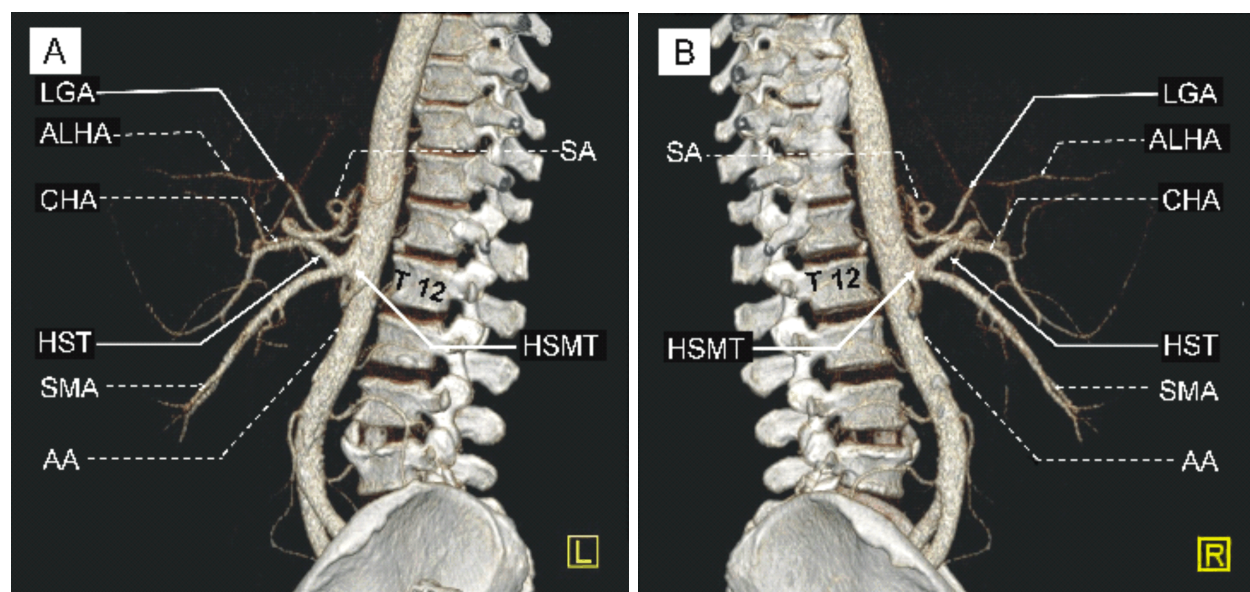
MDCT angiography of the AA. Rendered 3D images show the LGA and HSMT originating from the AA: (A) Left aspect; (B) Right aspect. MDCT: Multidetector computed tomography; AA: Abdominal part of aorta; 3D: Three-dimensional; LGA: Left gastric artery; HSMT: Hepato-spleno-mesenteric trunk; HST: Hepato-splenic trunk; CHA: Common hepatic artery; SA: Splenic artery; SMA: Superior mesenteric artery; ALHA: Accessory left hepatic artery.
